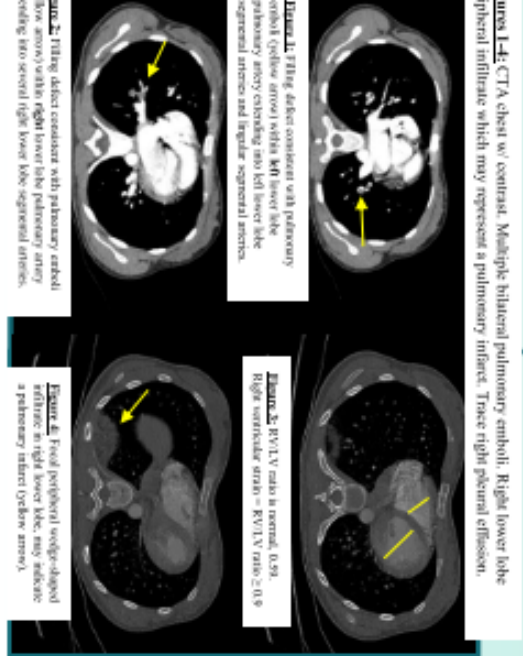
CTA chest w/ contrast. Multiple bilateral pulmonary emboli. Right lower lobe peripheral infarct which may represent a pulmonary infarct. These right pleural effusion.
